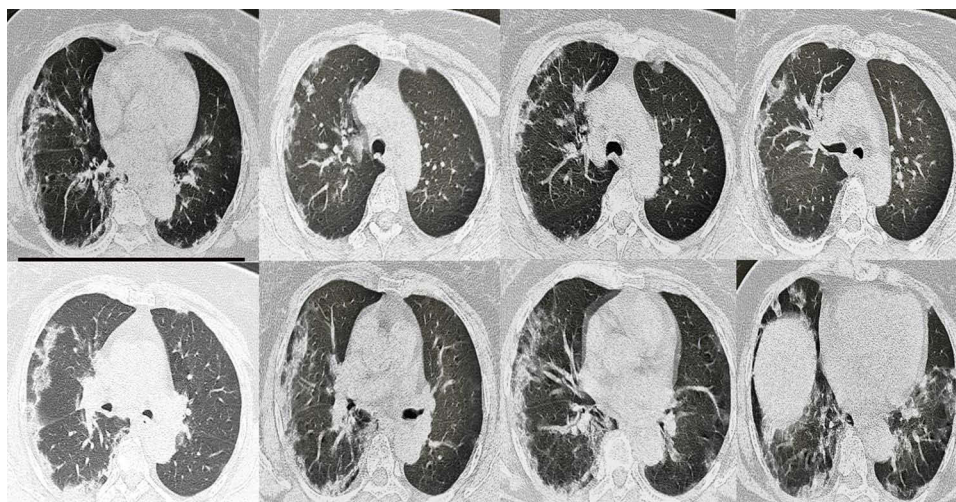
Chest computed tomography in a 44-year-old woman showing bilateral ground glass opacities.
